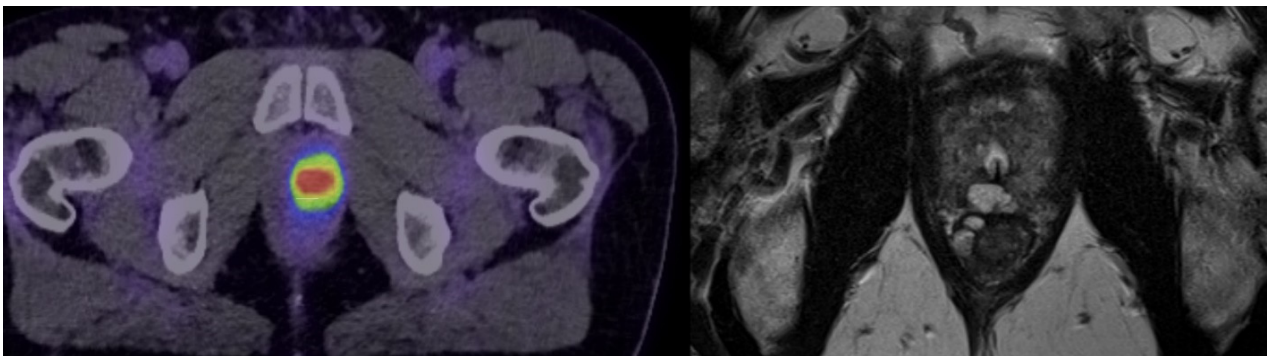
Example of an MRI-occult lesion (transverse imaging), which was not visible on mpMRI and classified as PI-RADS 2 (image on the right). However, the lesion was detected as a PSMA-avid lesion on 18F PSMA PET/CT (image on the left). MRI-occult lesions are those that do not show up clearly on MRI scans but are detected using alternative imaging techniques, such as PSMA PET. Abbreviations: Prostate Imaging–Reporting and Data System (PI-RADS), prostate-specific membrane antigen positron emission tomography (PSMA PET), multiparametric magnetic resonance imaging (mpMRI).
